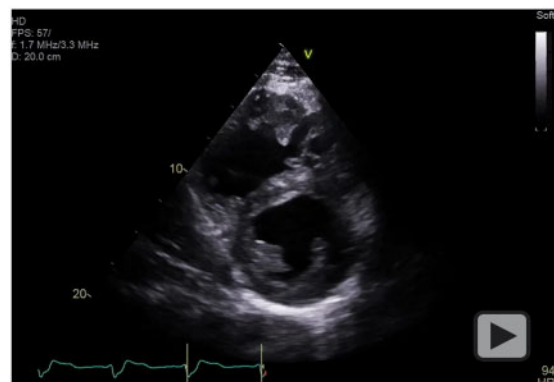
Two-dimensional transthoracic echocardiography demonstrating apical four-chamber and short-axis views of the right ventricle and left ventricle before transcatheter pulmonary valve replacement with biventricular dysfunction, right ventricle pressure and volume overload and hyper-trophy and apical left ventricle thrombus (A and B) and post-transcatheter pulmonary valve replacement with interval improvement in right ventricle pressure overload and biventricular function (C and D).
